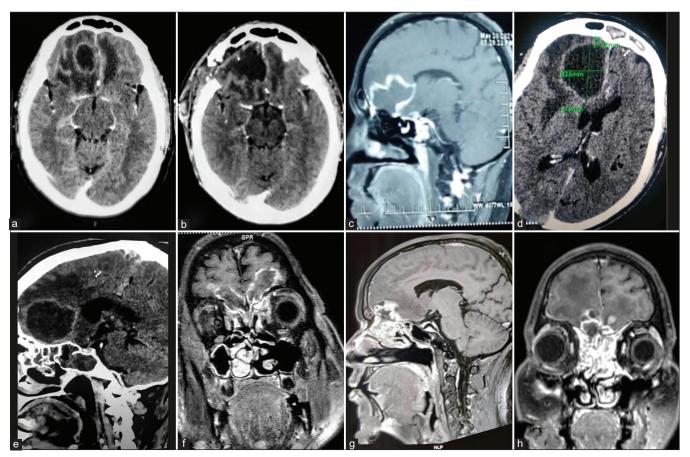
(a and b) Preoperative and postoperative contrast-enhanced computed tomography (CECT) images of the brain showing complete excision of the right frontal lobe abscess. (c-e) Rhinocerebral mucormycosis (RCM) cases presented as huge unilateral frontal lobe abscesses. (f-h) Cases of RCM with bilateral basifrontal extension of the lesion through the cribriform plate.
